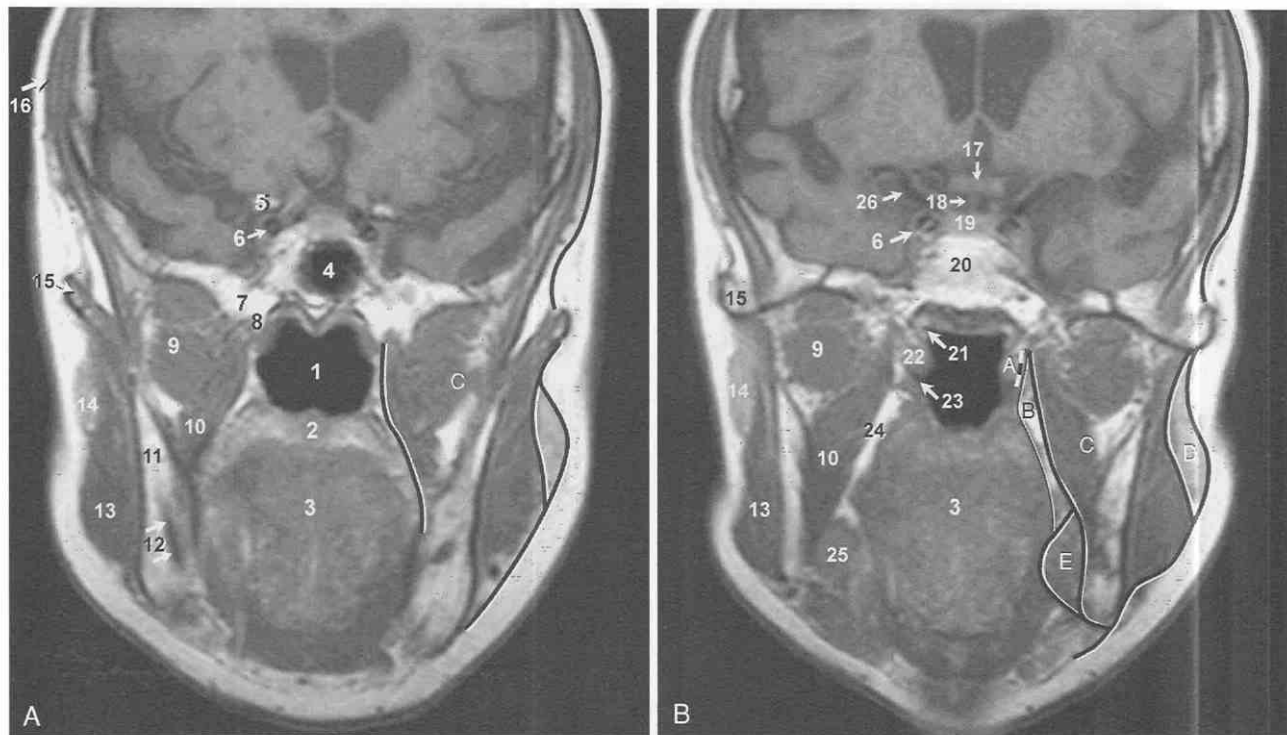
A–D, Normal imaging anatomy of the nasopharynx and oropharynx on a coronal non-contrast-enhanced, T1-weighted MR image. A, pharyngeal mucosal space (PMS); B, prestyloid parapharyngeal space (PPPS); C, masticator space (MS); D, parotid space (PS); E, submandibular space.
